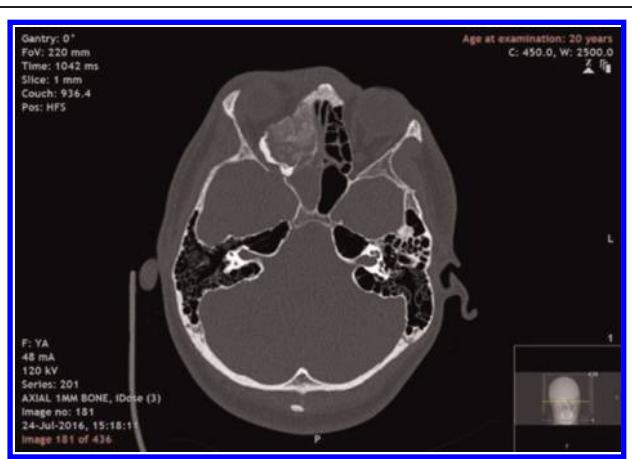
Preoperative axial computed tomography.
